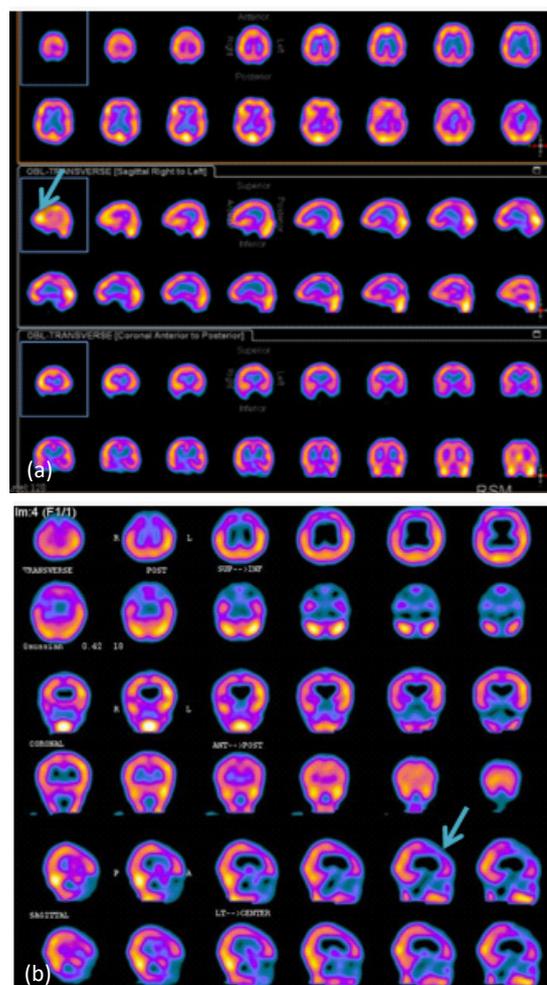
(a) SPECT brain perfusion obtained during ictal phase showing increased uptake (arrow) in right frontotemporal region (Hyperfrontality). (b) SPECT obtained during interictal phase showing decreased uptake (arrow) in right frontotemporal region (Hypofrontality).
